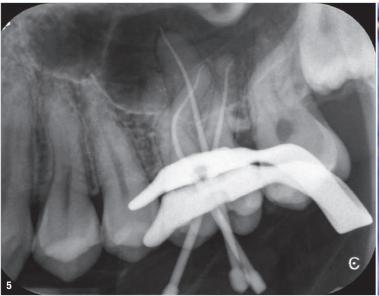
Master point radiograph. Fig. 6: EDDY irrigation tip.
